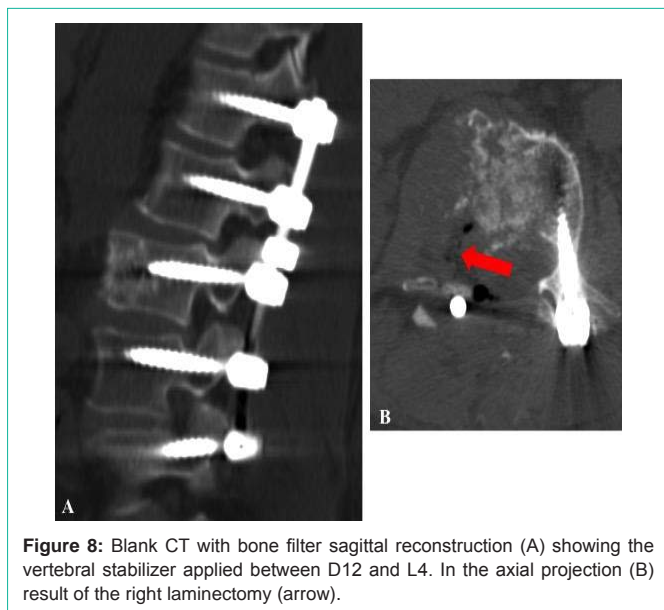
Blank CT with bone filter sagittal reconstruction (A) showing the vertebral stabilizer applied between D12 and L4. In the axial projection (B) result of the right laminectomy (arrow).
